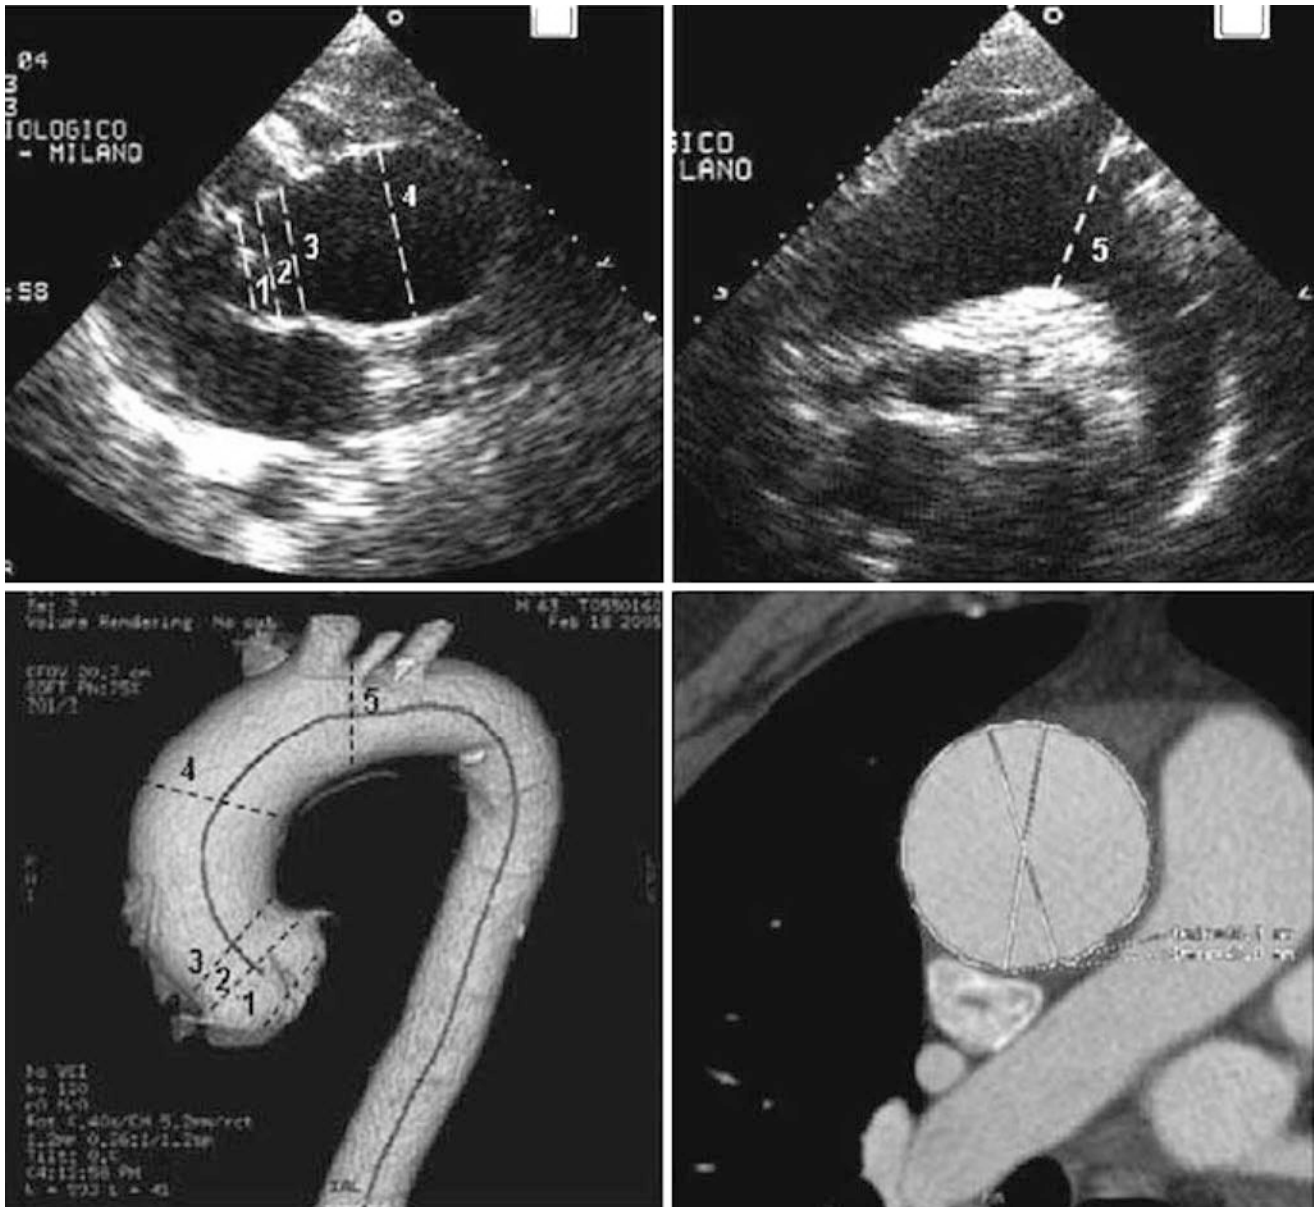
Example of measurement of the ascending aortic dimensions on transthoracic echocardiography (upper panels) and CTA (lower panels; [17])
